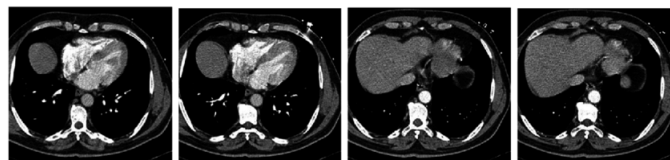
Example of a two dimensional cardiac CT [27]
